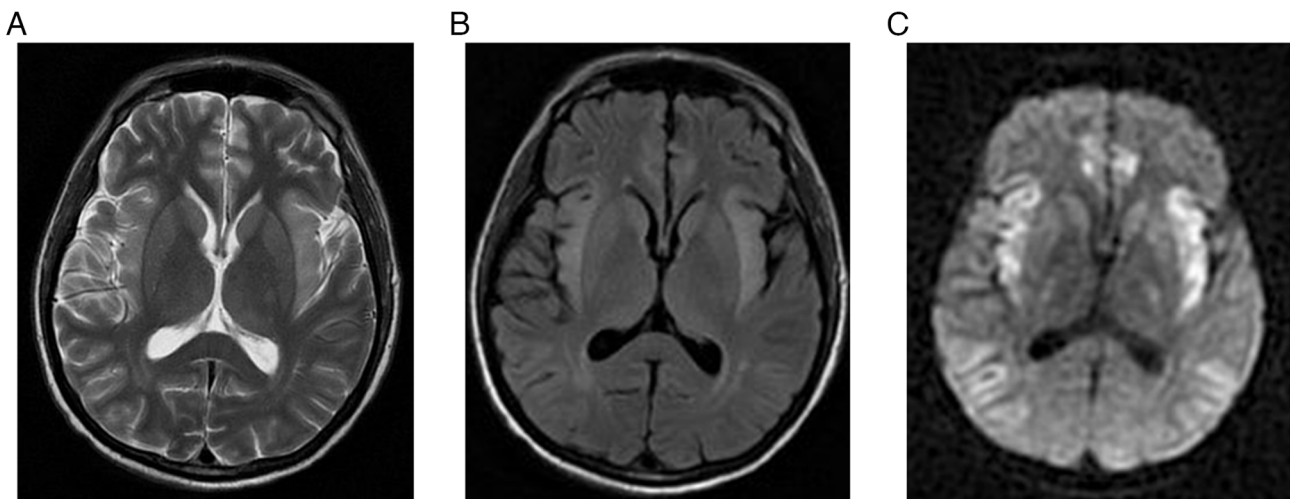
Follow-up MRI brain scan for case 1 after 2 weeks. (A) T2-weighted MRI, (B) fluid attenuated inversion recovery image and (C) diffusion-weighted imaging demonstrating slight interval progression of symmetric cortical high T2 and FLAIR signal intensities involving the bilateral insular cortex, temporal lobes, cingulate gyri and bilateral thalami. Mild regression of diffusion restriction suggests evolutionary changes. Interval generalized atrophic brain changes are noted, evidenced by a prominent ventricular system and cerebral sulci. MRI, magnetic resonance imaging.
